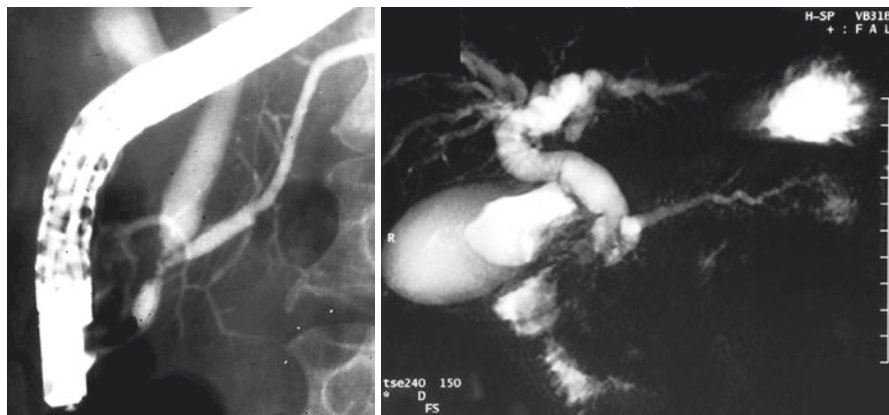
X-ray picture from an ERCP showing a typical double duct sign
